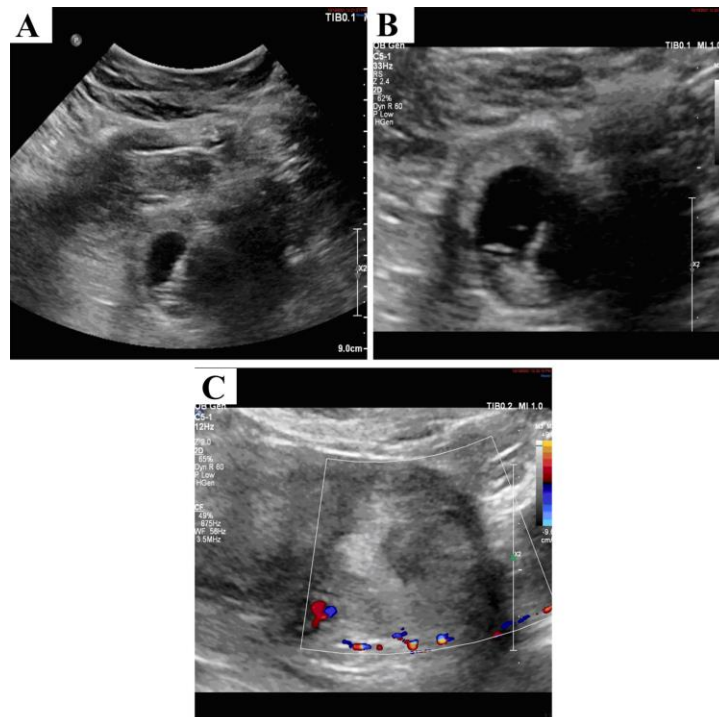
A and B; local injection of MTX and KCL under the pelvic ultrasound guidance shows the needle directed into the cardiac fetal activity. C; post aspiration of amniotic fluid and injection of MTX shows a nonvascular bulky heterogeneous anterior lower myometrial region without any fetal cardiac activity.
